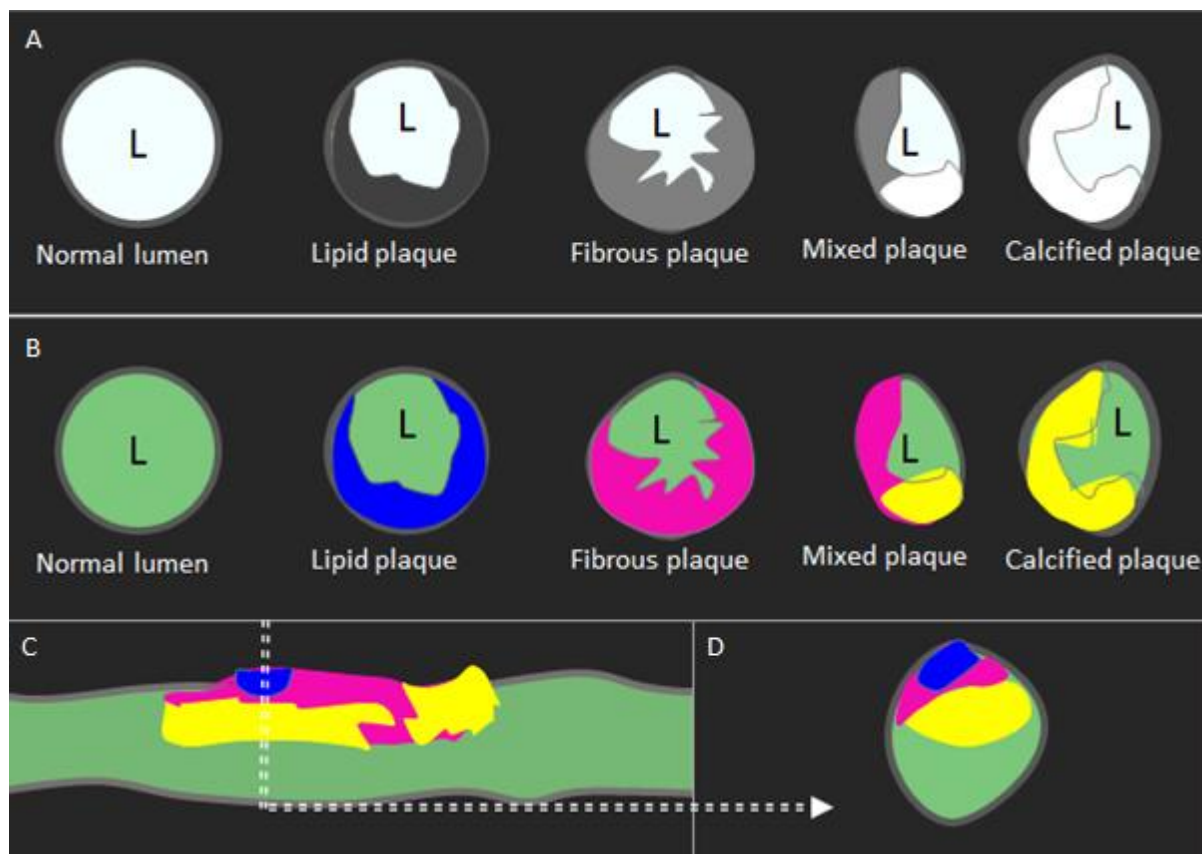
Representation of grey scale and colour mapping of coronary artery plaque based on CT Hounsfield units
